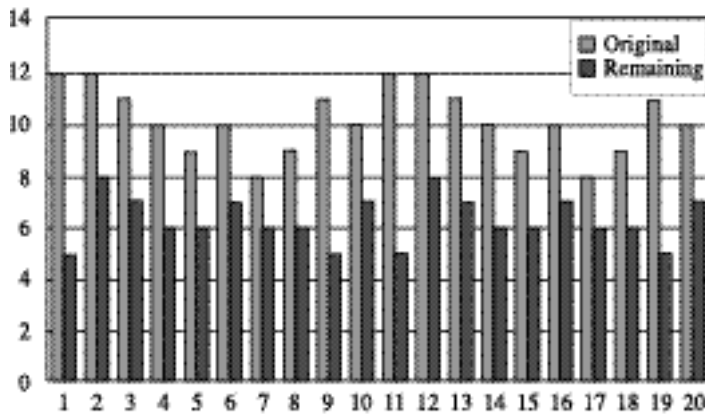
The shrinkage of CT from original position(mm)
